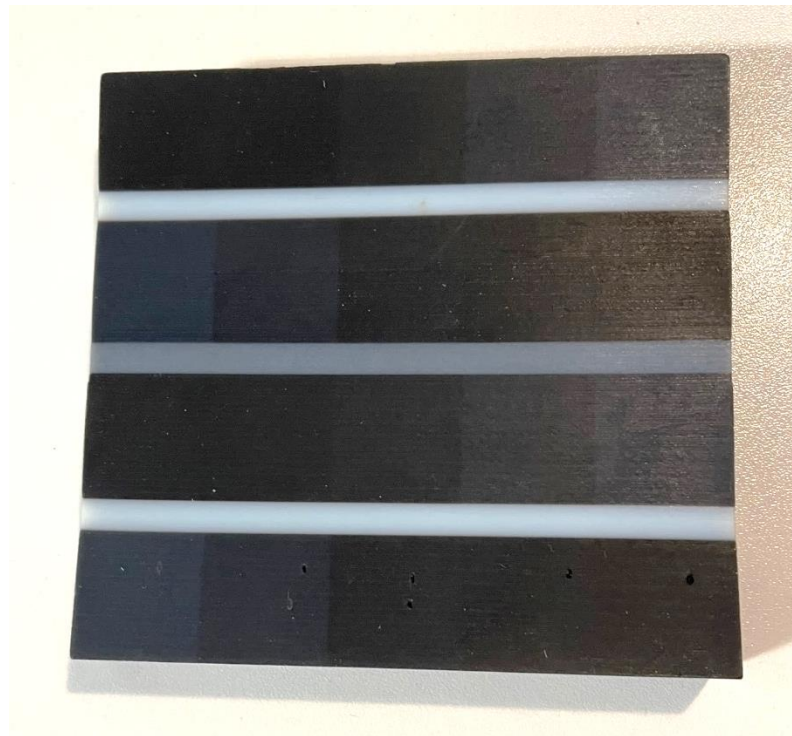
Top: Photograph of checkerboard sample; Bottom: corresponding CT scan in water. Result demonstrated no discernible contrast horizontally between different Agilus Black rigidities, but contrast was exhibited in the vertical direction between the Vero White and the Agilus Black sections of approximately 20 - 24 HU (1 s.d. of approximately 5 HU)
